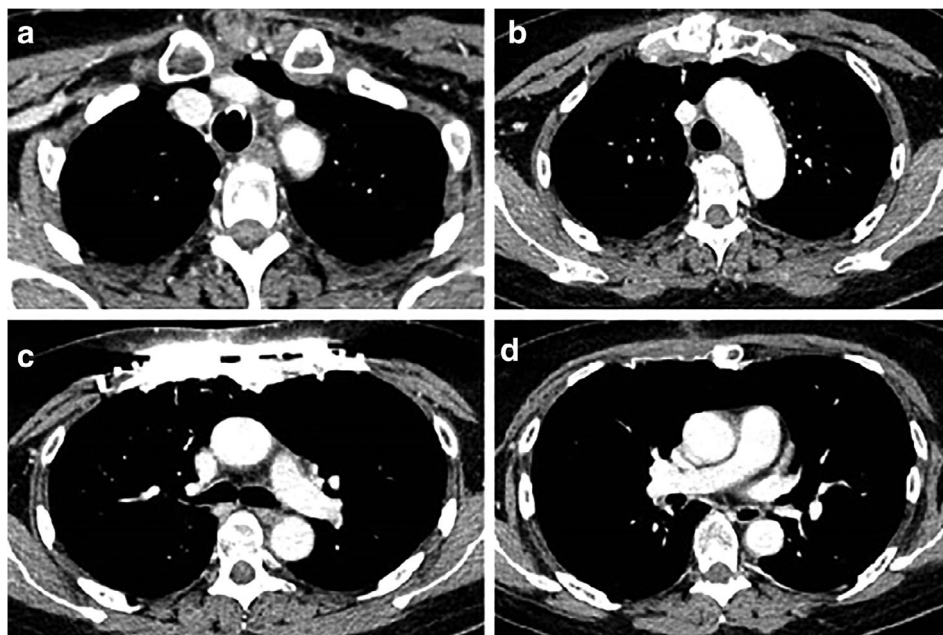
Postoperative axial view chest CT.
